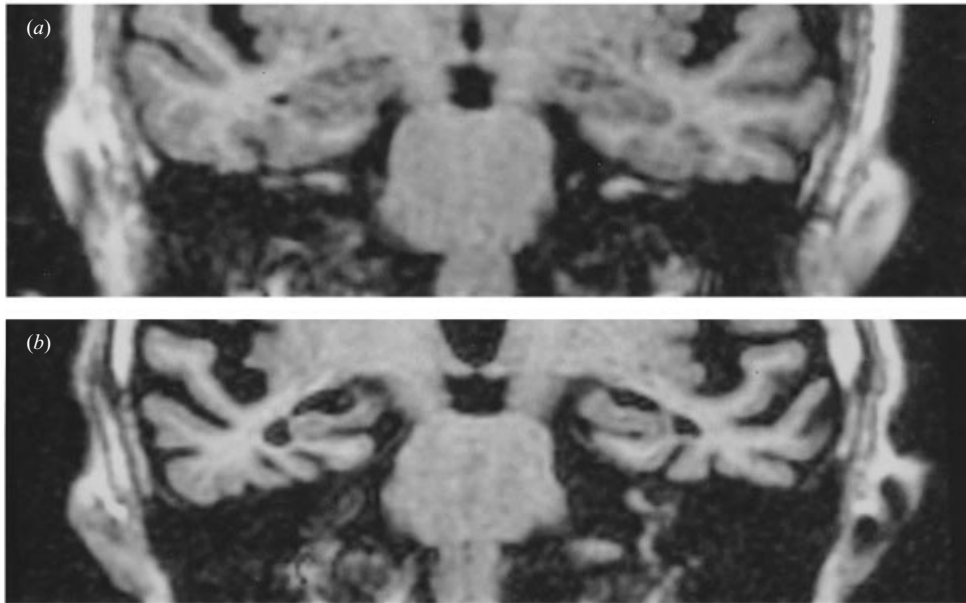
Sample coronal MRI scans of medial temporal lobe showing : (a) relative absence of medial temporal atrophy (combined visual rating 0) in a subject with dementia with Lewy bodies; and (b) severe MTA (combined visual rating 6) in a patient with Alzheimer's disease. Post-mortem confirmation of diagnosis has been obtained in both these cases.
